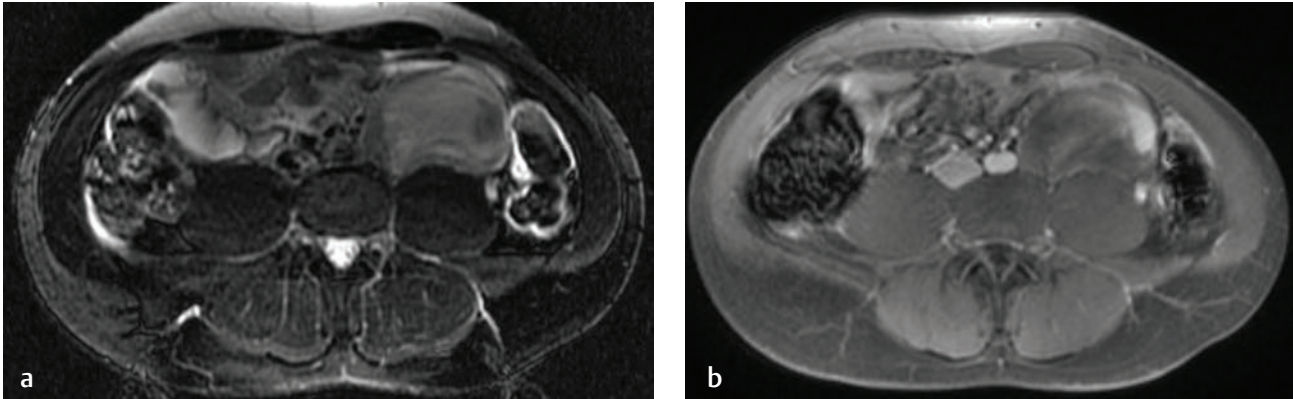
Left-side paraspinal ganglioneuroma. (a) An axial T2-weighted fat-suppressed image shows a lesion adjacent to the vertebral body and anterior to the psoas muscle. The lesion is hyperintense compared with muscle. (b) An axial postgadolinium T1-weighted image shows the lesion to be isointense compared with muscle, with sparse intralesional and peripheral enhancement.
